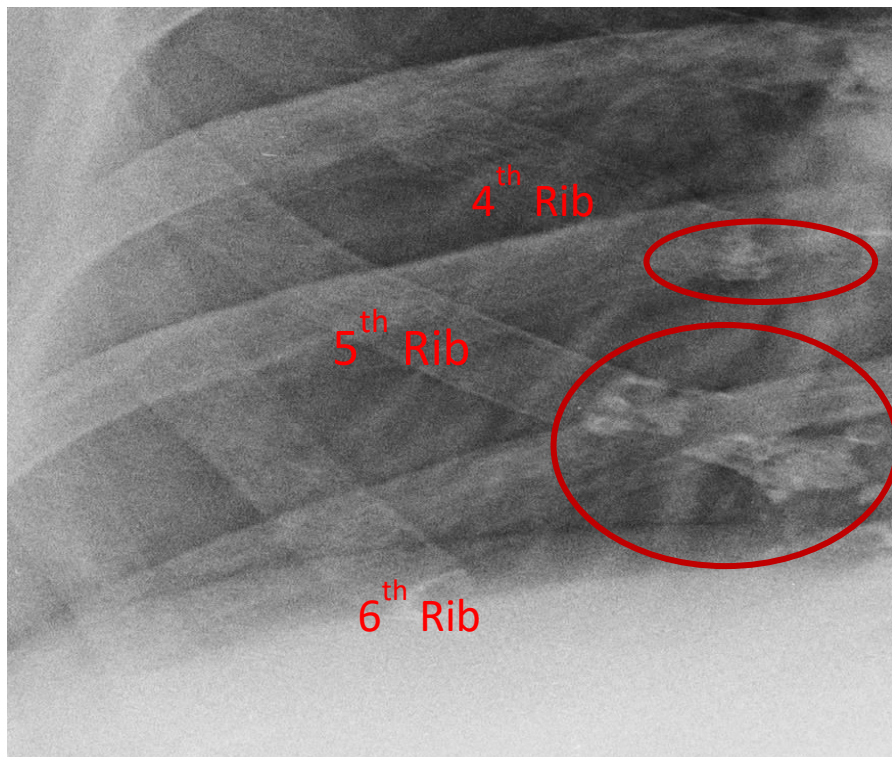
Central type of CCC observed on a female radiograph
